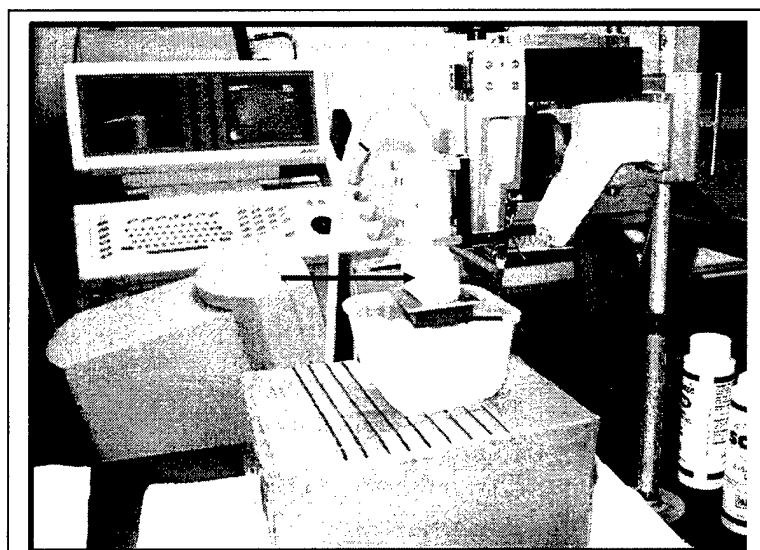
Data Acquisition Setup. The prostate gland is embedded in toweling and flooded with normal saline. The ultrasound probe (long black arrow) is held vertically and compresses the gland driven by a computer controlled stepper motor. The standoff gel block is held in place by the reddish orange plastic block (short black arrow) attached to an aluminum pressure plate attached to the transducer.
